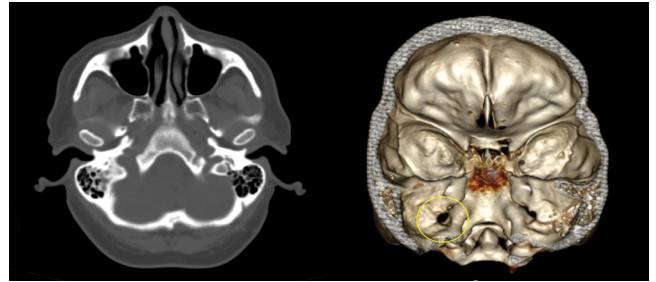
CT showing widening of jugular foramen.
